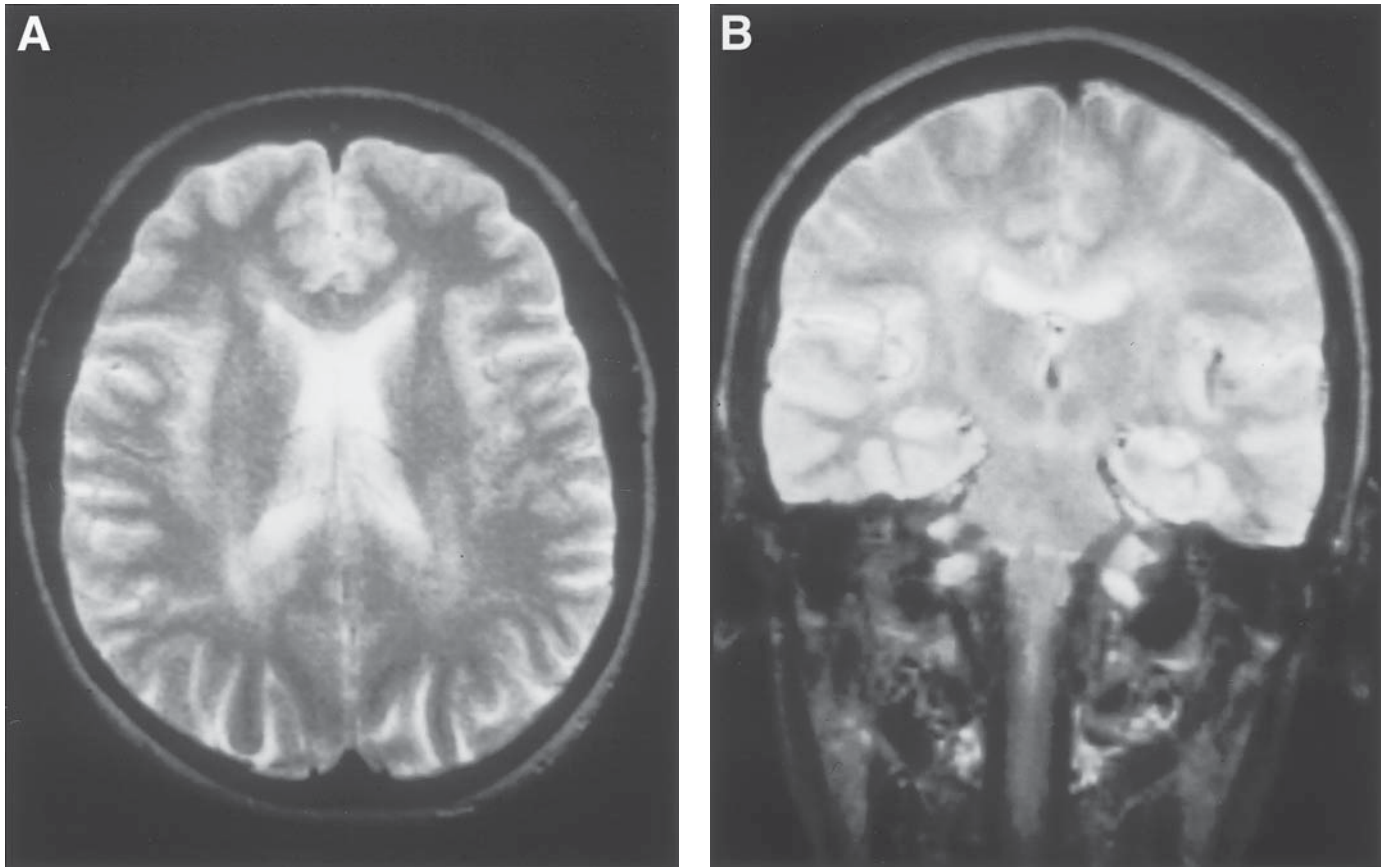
Leukoencephalopathy in a woman with colon adenocarcinoma treated with 5-FU and leucovorin. She presented with ataxia and confusion. She was found later to have profound DPD deficiency with no detectable enzyme activity. (A) T2-weighted axial MRI shows hyperintensity in periventricular white matter. (B) Coronal MRI shows periventricular white matter changes, as well as involvement of the deeper white matter and corticospinal tracts, sparing U-fibers. (Figures courtesy of Robert Diasio MD, Chairman, Department of Pharmacology & Toxicology, University of Alabama at Birmingham.)
